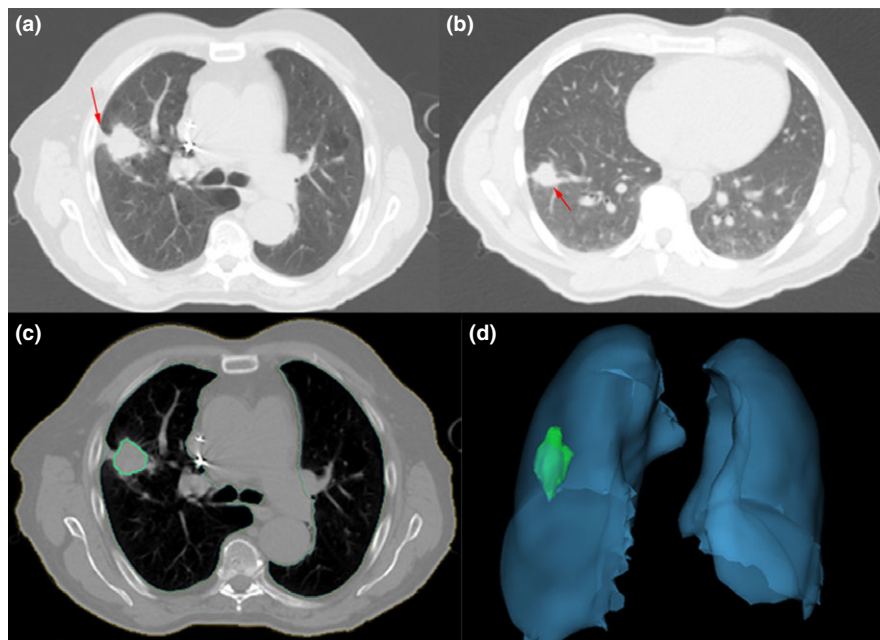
Examples of CT images showing typical semantic features and tumor segmentation (a): tumor with pleural retraction; (b): tumor with vessel attachment; (c): one slice showing lung and tumor segmentation; (d): 3D view of lung and tumor segmentation). [Color figure can be viewed at wileyonlinelibrary.com]
